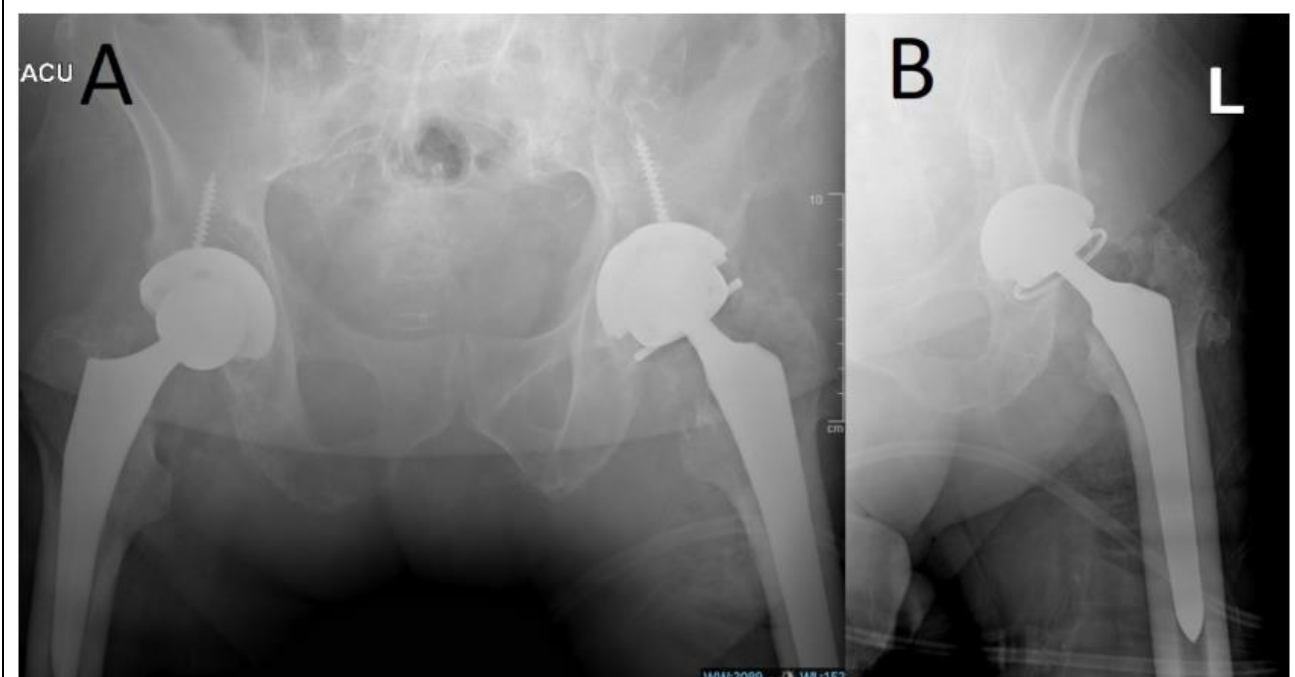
3A-3B Radiographs (Case 1). Postoperative anteroposterior pelvic (A) and anteroposterior left hip (B) radiographs following left hip revision arthroplasty.
